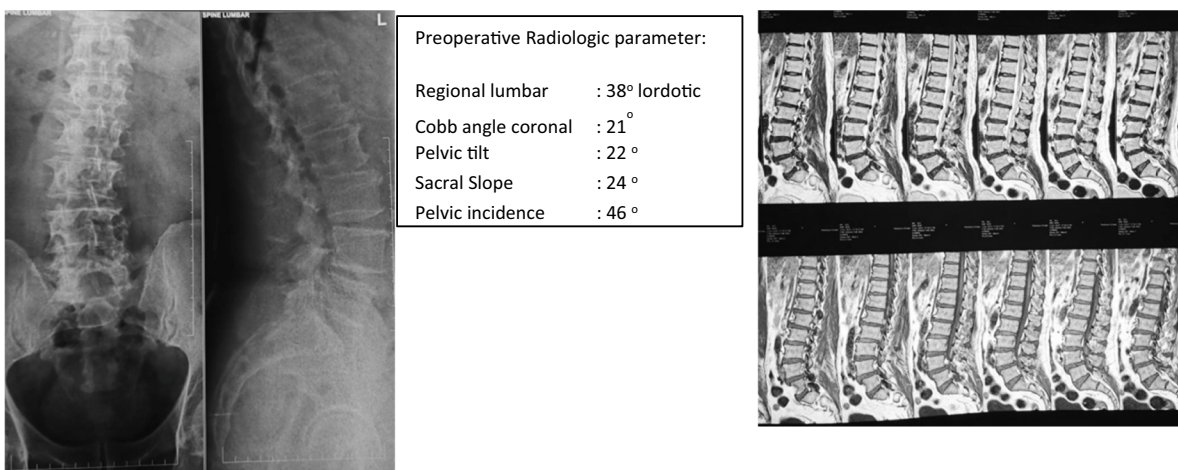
Case 2 initial radiograph presentation.
